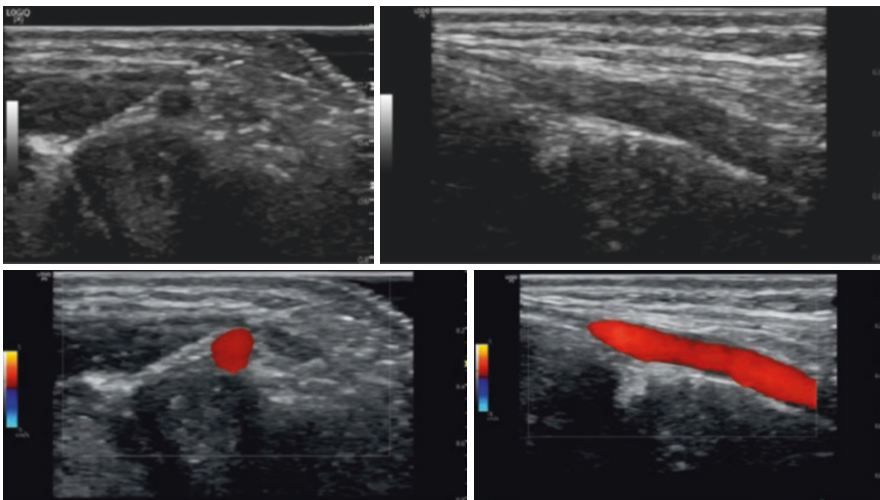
2D image and color doppler of the dorsalis pedis artery in short and long axis views
